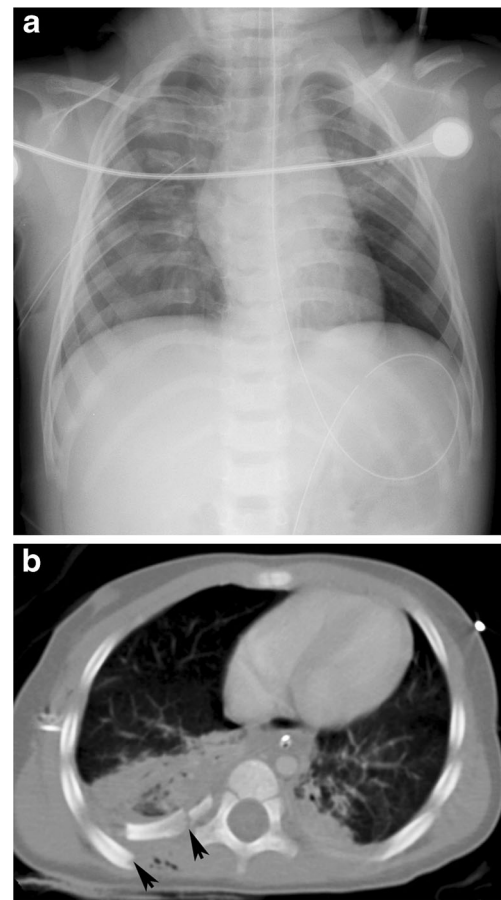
Imaging in a 14-month-old boy who was unresponsive in the field after he was backed over at low speed by a sport-utility vehicle. He sustained cranial injury with basilar and temporal skull fractures, subdural hemorrhage, right internal carotid occlusion with secondary middle cerebral infarction, left clavicle fracture, atlanto-axial strain and multiple thoracic injuries. a Initial anteroposterior chest radiograph shows multiple traumatic injuries including right-side fractures of ribs 2–9 posteromedially. More laterally, ribs 3–10 have fractures. A moderate pleural effusion layered out posteriorly. There is an acute left clavicular fracture. b Axial CT image obtained on the same day shows a right-side segmental rib fracture (*arrowheads*) with air in the extrathoracic soft tissues. Underlying pulmonary contusion and pleural effusion are present. Deep pulmonary injury is more frequent in accidents than in abuse
